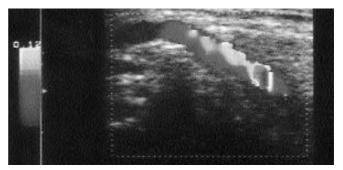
Patient without temporal arteritis: A color Doppler longitudinal scan shows normal proximal superficial temporal artery.
